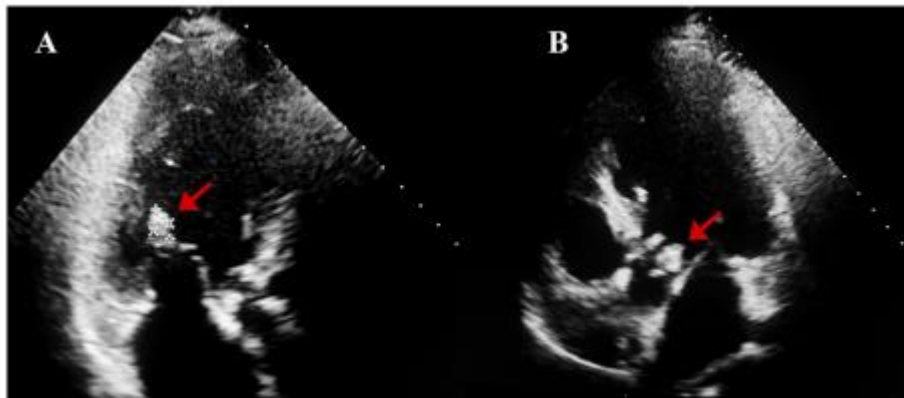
Transthoracic echocardiogram showing multiple vegetation's
